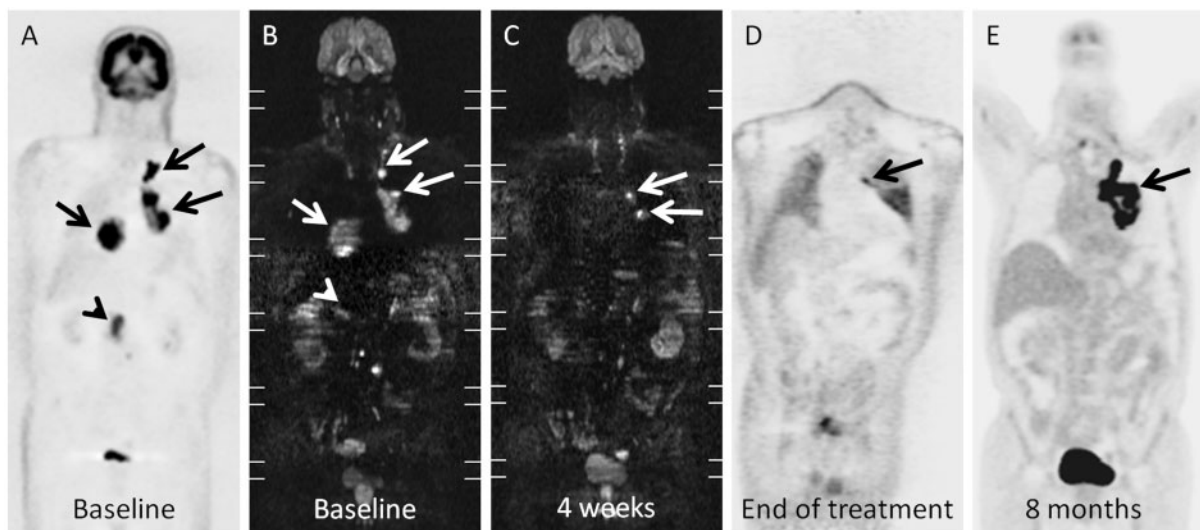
(A) Baseline FDG-PET and (B) WB DWI b1000 image shows a patient with stage III NHL with mesenteric adenopathies (arrowhead), right and left hilar as well as left upper mediastinal adenopathies (arrows). (C) MPR coronal reformatted WB DWI b1000 image at 4 weeks during treatment shows persisting hyperintense areas in the left hilar adenopathies with an ADCratio_{4w} below the threshold of 40%. (D) FDG-PET at end of treatment shows residual uptake in the left hilar area. (E) FDG-PET at 8 months after completion of treatment shows a large metabolic left hilar mass compatible with tumour relapse.
